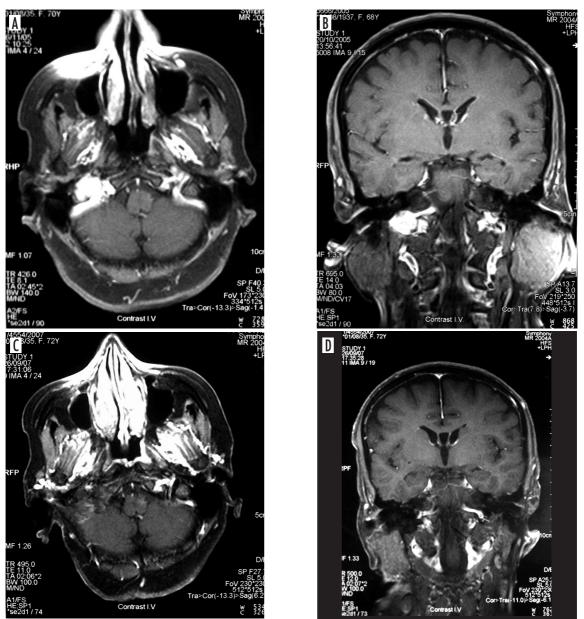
Jugular foramen paraganglioma spreading into hypotympanum on the right side (patient no. 7, 70-year-old female). The patient developed dysphagia and pulsatile hum in the head within 6 months. Tumour volume was assessed as 3 cm<sup>3</sup>. She underwent surgical treatment with the first range approach implemented. The tumour did not reach the neural compartment of the foramen. Dysphagia diminished following surgery. A) preoperative axial MRI, B) preoperative coronal MRI, C) postoperative axial MRI, D) postoperative coronal MRI
